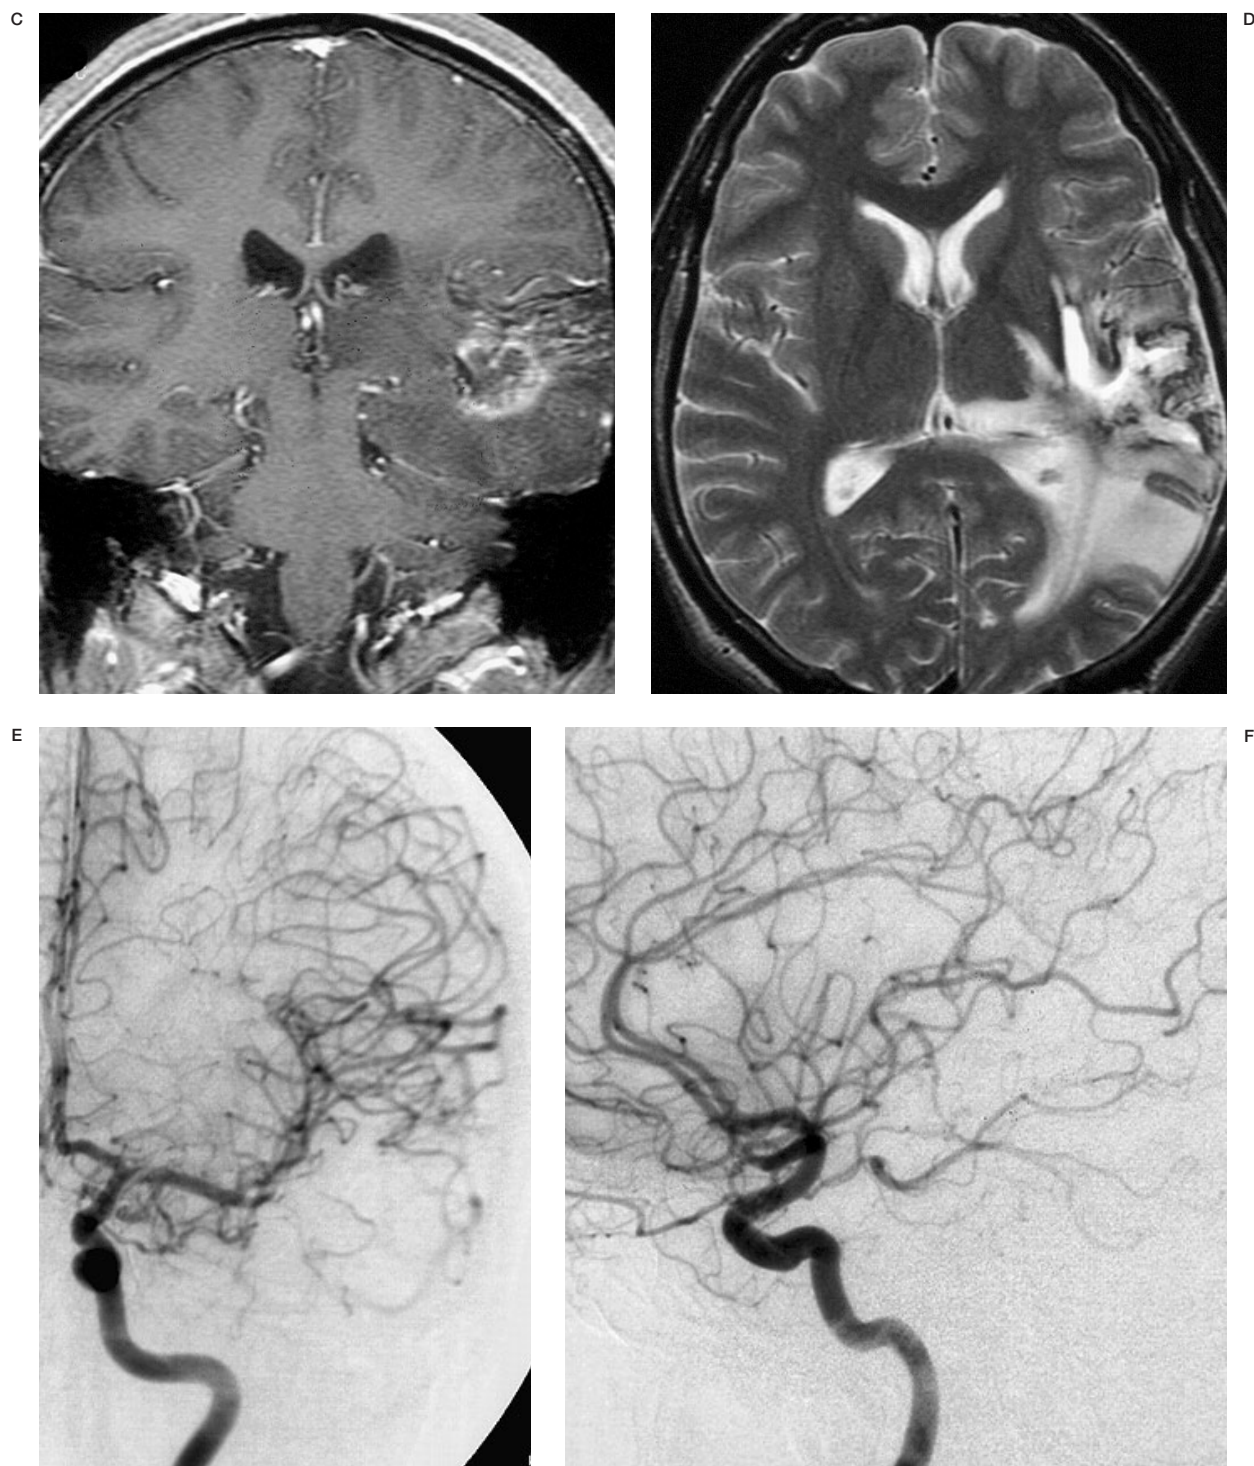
Case 10. A 24-year-old man with a left temporal arteriovenous malformation presenting symptoms of epilepsy, language problems and homonymous quadrantanopia (A,B). After three embolization sessions to reduce the malformation, stereotactic radiosurgery was performed on a volume of 14.6 cm³ with a treatment dose of 16 gray. Six months post radiotherapy the patient reported mild amnesia, difficulties to understand spoken language and, while he was under antiepileptic treatment, an epileptic crisis. Post contrast T1 coronal (C) and axial T2-weighted (D) MRI images showed the characteristic ring enhancement and oedema of radionecrosis. Corticotherapy was instituted for five weeks. Seven months later these new symptoms had totally resolved. A control angiography performed two years after radiosurgery showed complete obliteration of the arteriovenous malformation (E,F).
